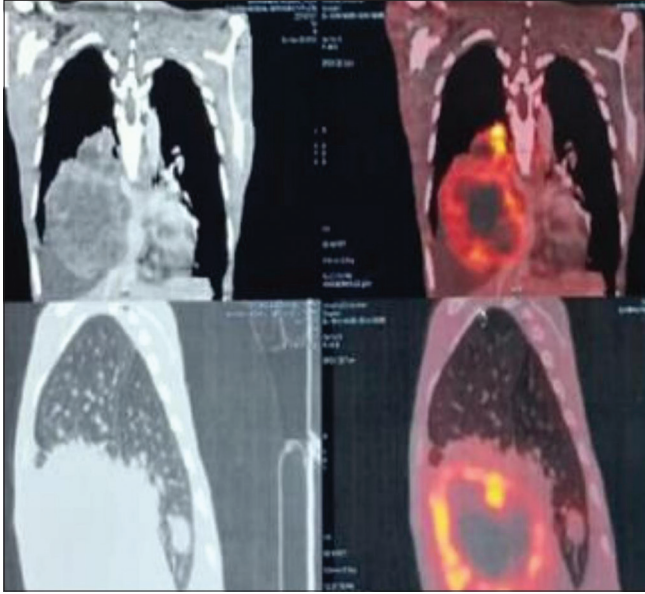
Positron emission tomography-computed tomography scan showing metabolically active (SUV max 7.5) large lobulated mass in anterior and middle mediastinum on the right side displacing mediastinal structures to the left.
